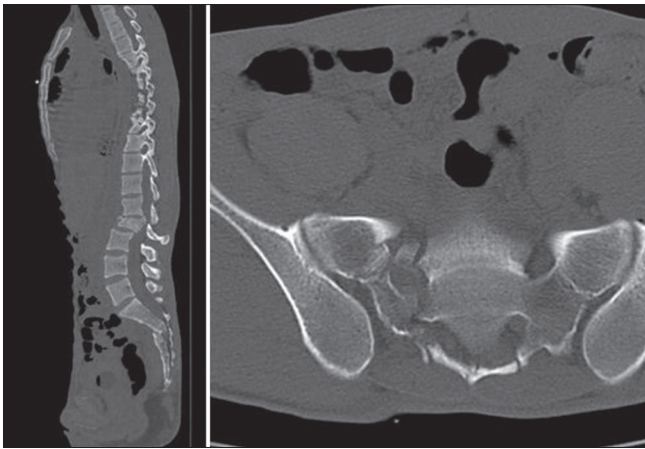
Pre-operative CT scan is demonstrating Bilateral transverse sacral fracture in Sagittal and Axial views
